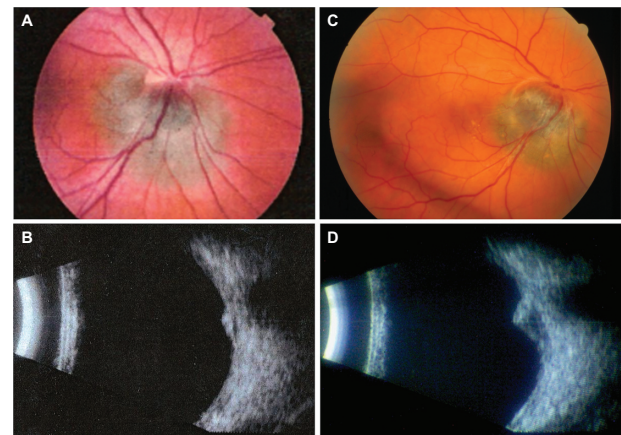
Clinical imaging for Case #2. A) Fundus photo of the right eye demonstrating pigmented juxtapapillary lesion which remained stable in appearance for several years. B) B-scan ultrasound of the lesion from (A) with apical height of 1.3 mm. C) Appearance of the same lesion two years later. Note invasion into superior optic nerve head tissue, optic disc hemorrhage, and displacement of central retinal vessels. D) B-scan ultrasound of the lesion from (C) showing marked increase in height to 3.4 mm, with associated basal dimensional growth.
